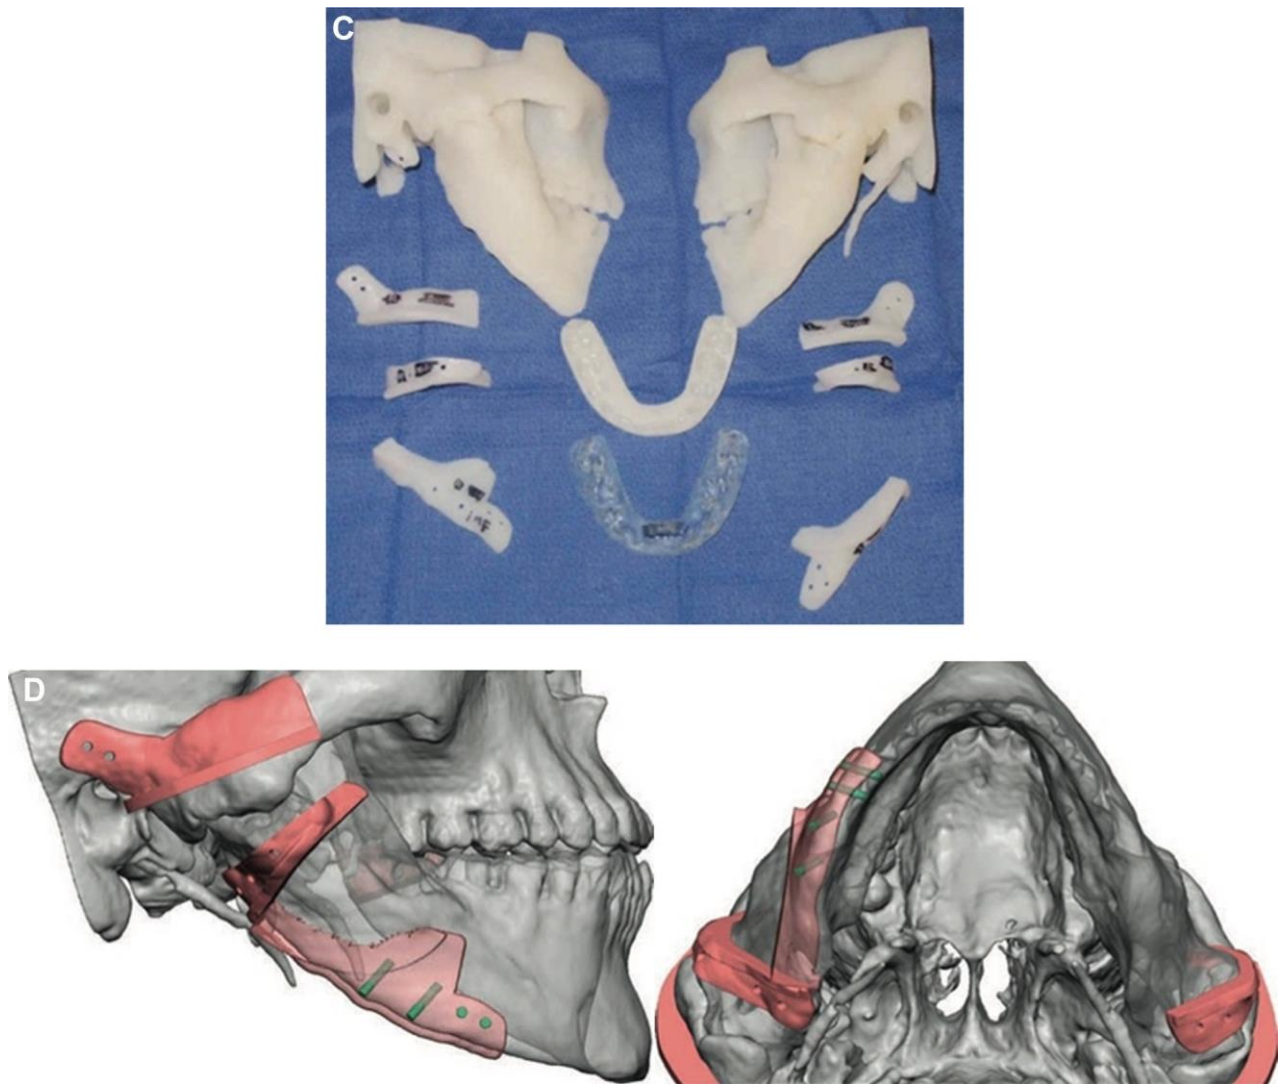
(cont'd). C, Model and surgical guides. D, Surgical guides overlaid on CT scan. (Fig 57 continued on next page.)
